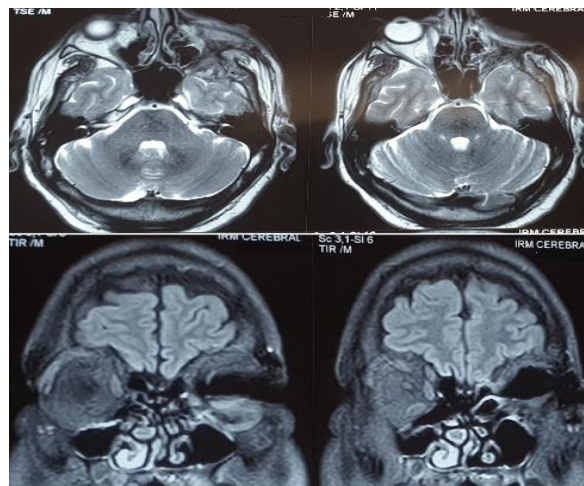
10 months post-operatively MRI of brain and orbit showing an empty orbital compartment
